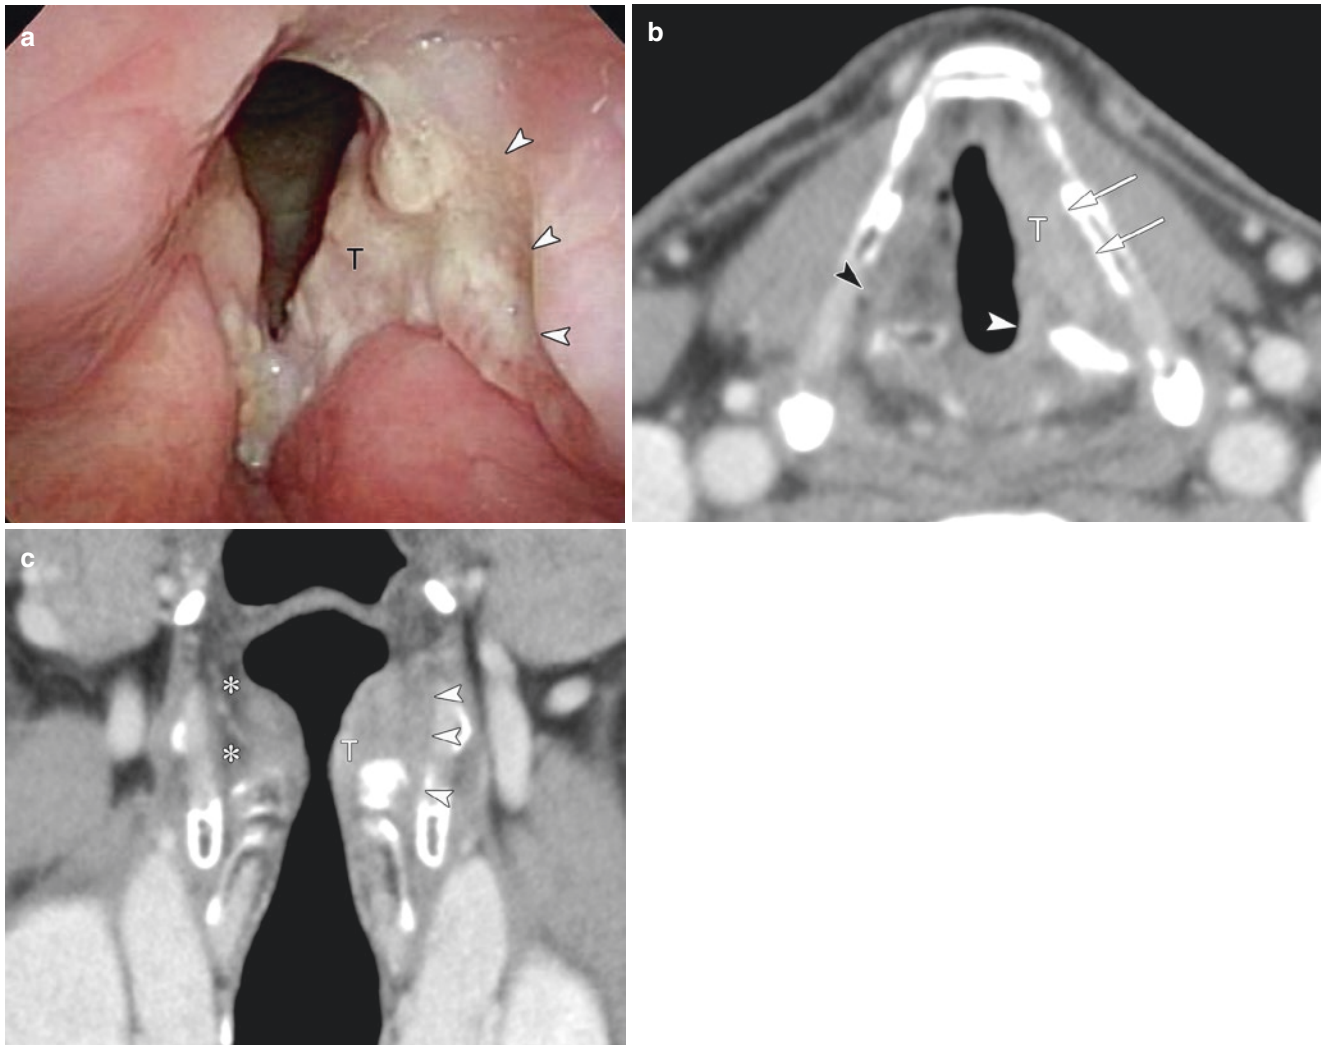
Glottic cancer with radiologic paraglottic space infiltration and superior extension. On the laryngo-fiberscope (a), a mass lesion (T) involving the left vocal cord with infiltration into the left supraglottis was observed. The mobility of the vocal cords was clinically favorable. Axial contrast-enhanced CT (b) demonstrated an infiltrative tumor (T) involving the paraglottic space. Note the structure of the descending branch of the right superior laryngeal artery maintained on the right
